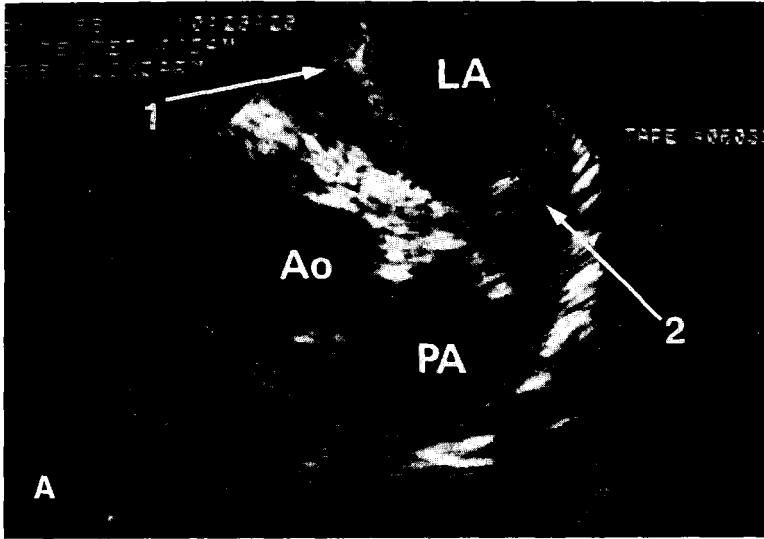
Transesophageal two-dimensional echocardiograms (3 and 5 MHz transducers, respectively) obtained in a patient with mitral valve stenosis and a history of peripheral embolism. A, Two mass lesions are identified in the left atrium (LA): one superiorly near the entrance of the right pulmonary veins (arrow 1) and one at the junction of the left atrial appendage (arrow 2). B, The cross sections obtained after 3 months of anticoagulant therapy reveal the resolution of both mass lesions. Abbreviations as in Figure 1.
